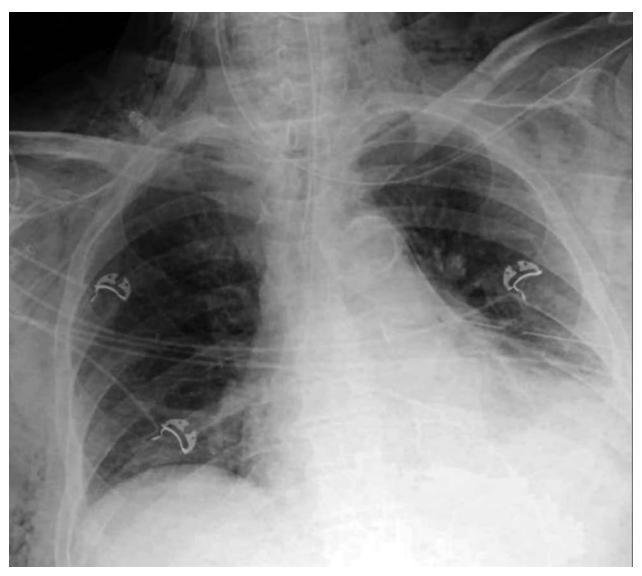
Chest radiograph after intubation and placement of a left sided chest tube demonstrating massive subcutaneous emphysema in the chest and neck.
